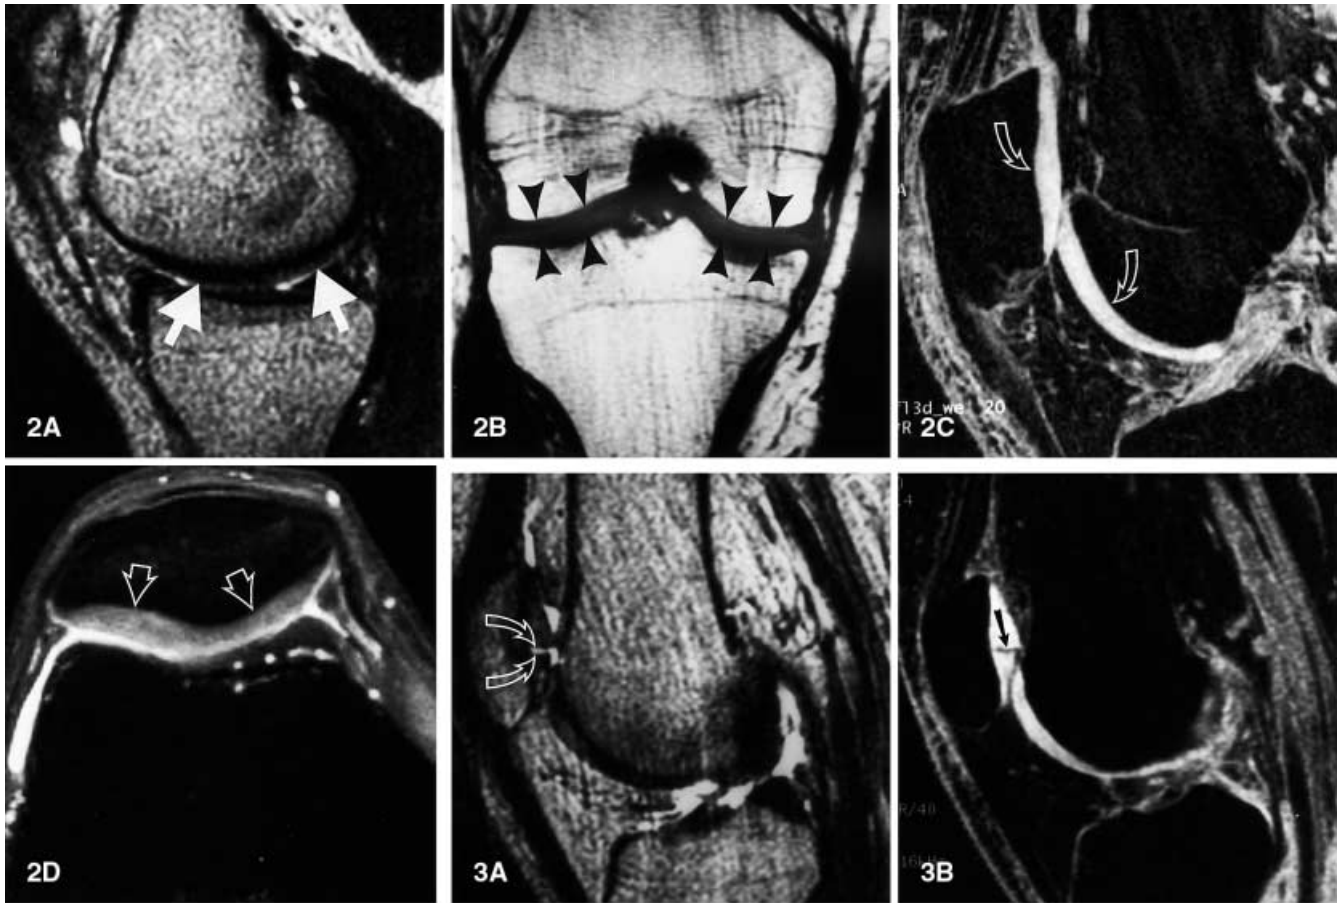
MR images of normal hyaline cartilage. A Sagittal T2-weighted spin-echo image (2600/80, TR ms/TE ms) shows articular cartilage (*arrows*) as a structure of diminished signal intensity similar to fat and subchondral bone. A small amount of joint fluid provides an arthrogram-like effect due to the higher signal intensity of fluid. B Coronal T1-weighted spin-echo image (500/12) shows articular cartilage (*arrowheads*) as of intermediate signal intensity compared with subchondral bone, which is of diminished signal intensity, and fat, which is of high signal intensity. (Even with photographic enhancement at the level of the joint line, discrimination is difficult between the femoral and tibial articular cartilage, and between articular cartilage and subchondral bone). C Sagittal fat-suppressed three-dimensional spoiled gradient-echo image (32/8; flip angle, 40°) shows articular cartilage (*arrows*) as a high-signal structure compared with adjacent tissues of diminished signal intensity. D Axial fat-suppressed intermediate-weighted fast spin-echo image (4500/15; echo train length, 7) shows articular cartilage (*arrows*) as an intermediate-signal structure compared with the higher signal intensity of fluid and the lower signal intensity of subchondral bone
